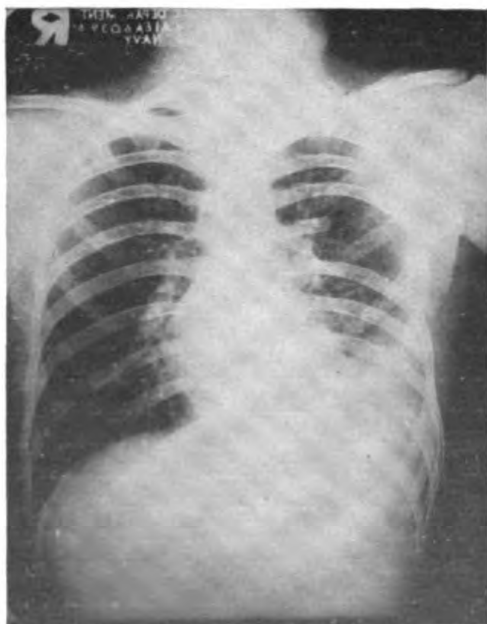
Case 1. Postoperative x-ray showing lung reexpanded to completely fill the left thoracic space following decortication. Fluid and thickened pleura are evident in the left base.
